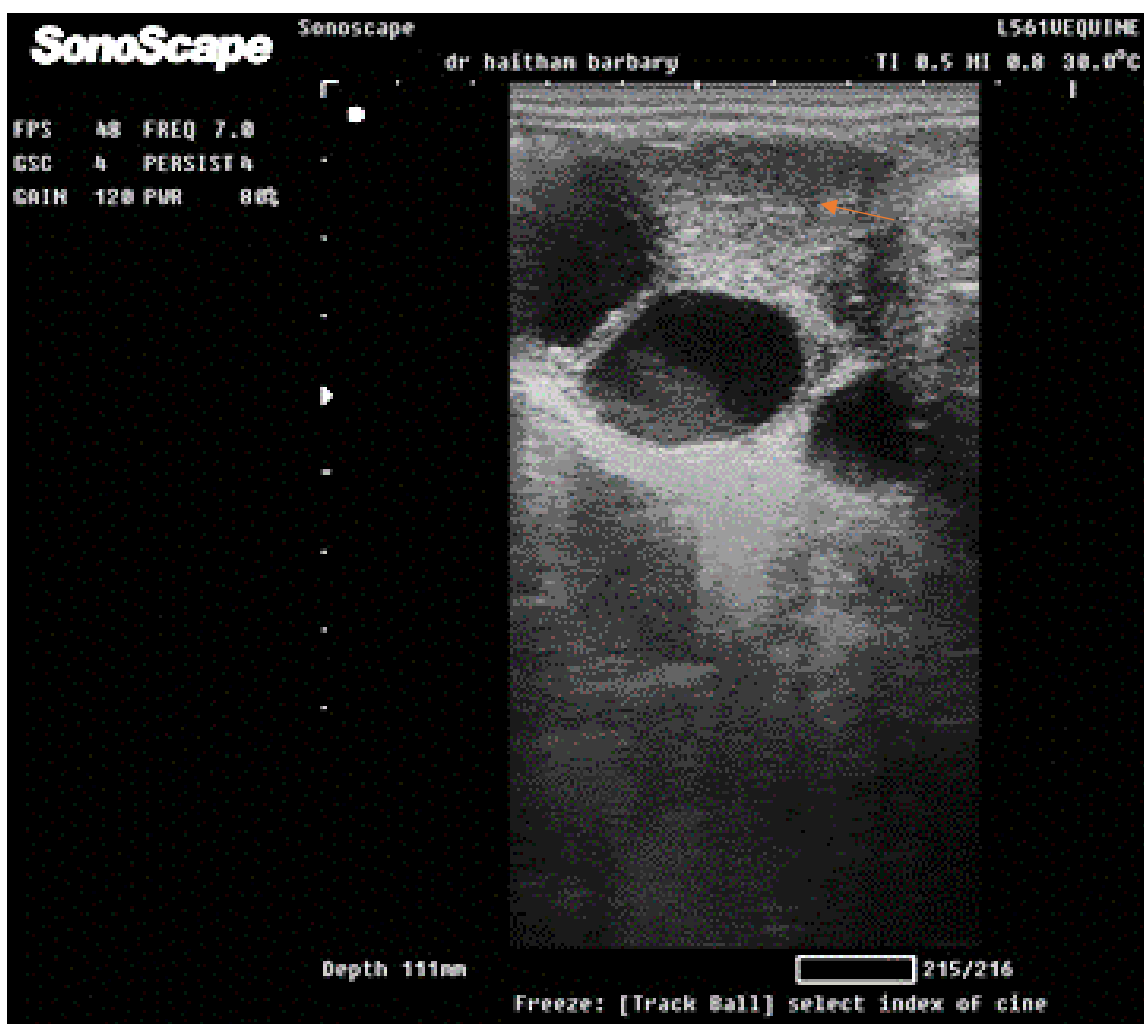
Ultrasonographic image of the ovary containing nonechoic (black) circular follicles and echoic CL (arrow)
